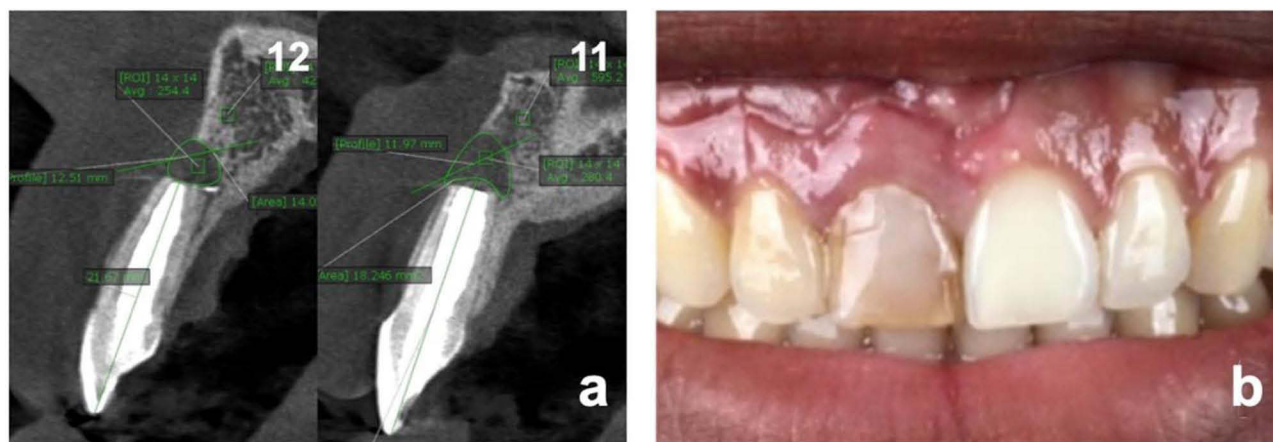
One week post-op. (a) Sagittal slices CBCT assessment shows bone defect after surgical removal of the lesions on #12, #11 (b) The sutures were removed at 1-week control, and the edges of the flap were already noticeably filled with connective tissue.
